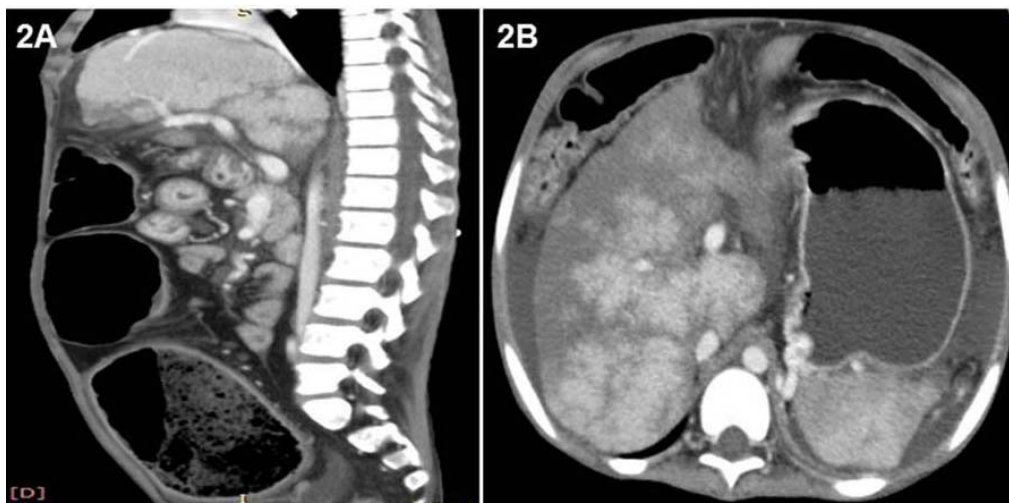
A) Longitudinal and, B) transverse views of the venous phase of triple phase CT abdomen, showing attenuation of all three hepatic veins with a patent IVC and patchy uptake of contrast and a hypertrophied caudate lobe
